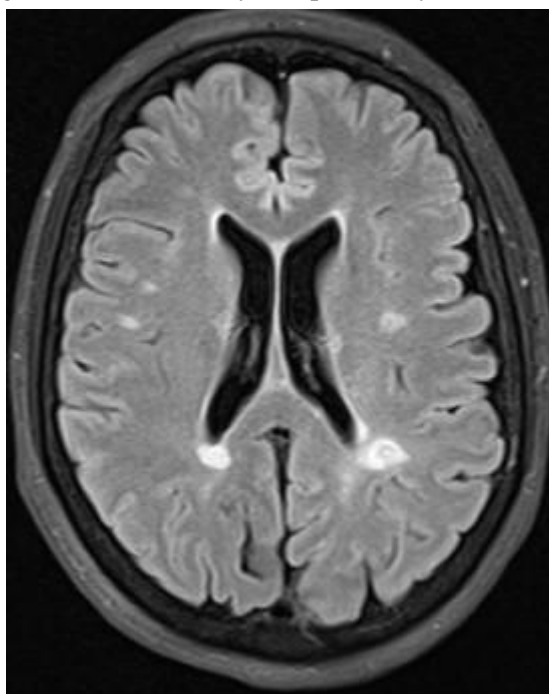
Magnetic resonance imaging (MRI) of brain of index patient: Axial Fluid Attenuated Inversion Recovery (FLAIR) image showing several ovoid hyperintensities in periventricular and subcortical white matter
